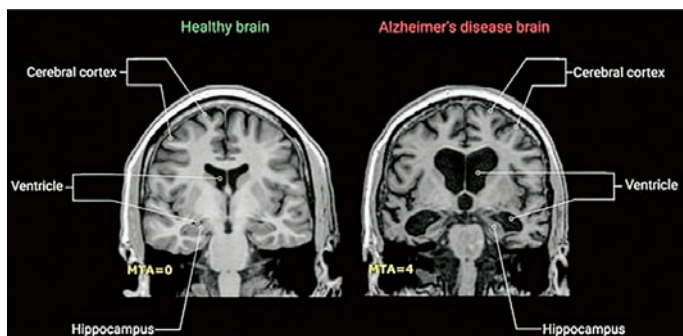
MRI of a healthy brain and a brain affected by Alzheimer's disease
